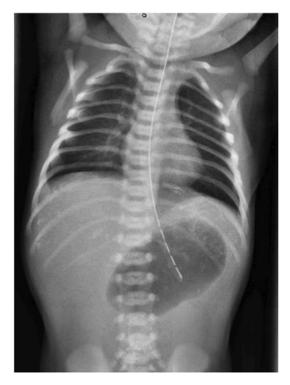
Abdominal X-ray performed on first day of life. Absence of gas below the gastric outlet suggests obstruction at the level of the gastric outlet or proximal duodenum. Clusters of calcifications in the left and right upper quadrants indicate prior antenatal intestinal perforation or meconium peritonitis.
